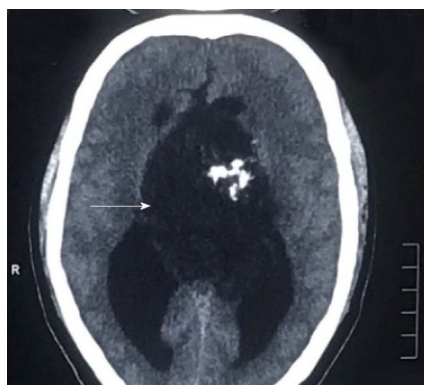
A non-contrast computed tomography scan of the head showing a mass arising from the third ventricle appearing hypodense and showing coarse nodular as well as curvilinear calcifications.
